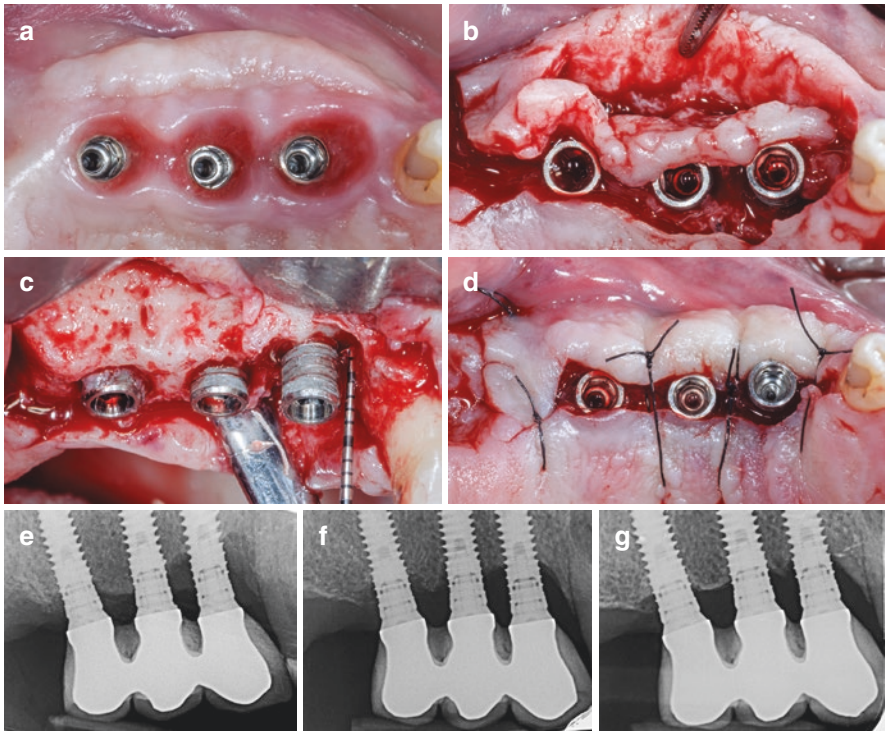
(a–g) Gingivectomy and decontamination of the surface to treat advancing periimplantitis. As a result, a good stability of the bone crest can be observed years later. Radiographs taken in 2014, 2016, and 2020
